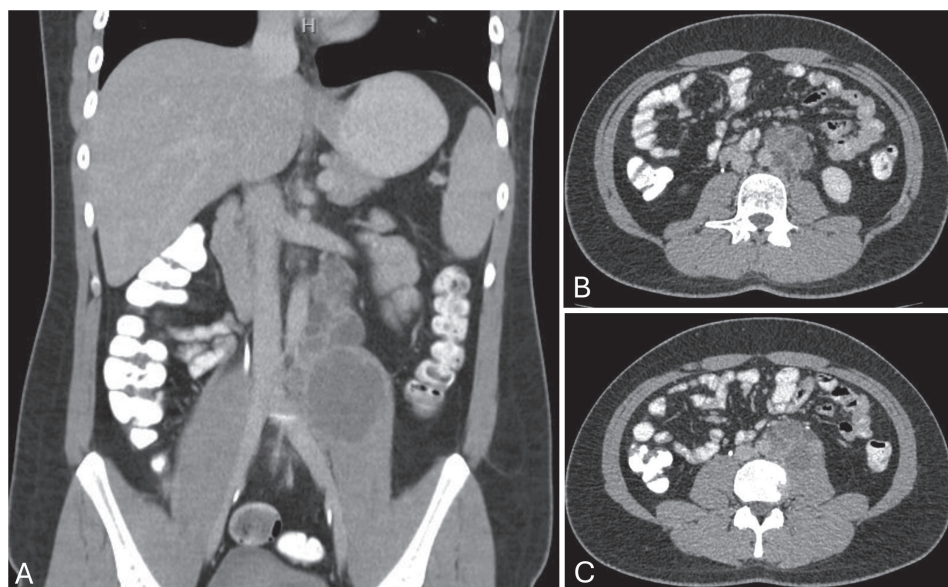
CT scan coronal (a); and axial views (b and c): of an EGGCT in a 24 year-old male with elevated serum tumour markers (mainly β -human chorionic gonadotropin). Percutaneous biopsy confirmed choriocarcinoma.
